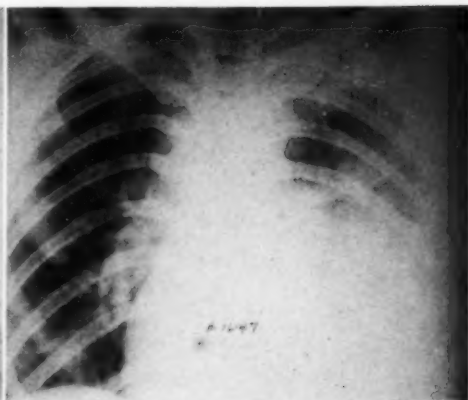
Left lower lobe pneumonia; patient critically ill; 200 roentgens to left anterior chest immediately after admission. Death on fourth hospital day. At no time was there any evidence of improvement in clinical symptoms. Treatment was not repeated because of leukopenia and marked granulopenia. The temperature chart is characteristic of all fatal cases in this series.
